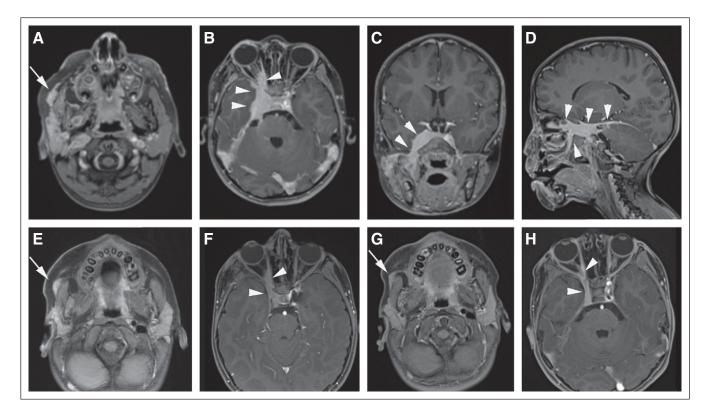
Perineural spread of squamous cell carcinoma (A to D) at time of diagnosis and (E to H) after therapy, shown by contrast-enhanced T1-weighted magnetic resonance imaging. (A) Axial image through face at level of parotid gland shows asymmetric nodular enhancement throughout right parotid gland, as well as more anterior nodular superficial enhancing tissue (arrow). (B) Axial, (C) coronal, and (D) sagittal images through head at level of cavernous sinus and right pterygopalatine fossa show extensive abnormal enhancing tissue within cavernous sinus, extending anteriorly into the right orbital apex, as well as posteriorly toward posterior fossa (arrowheads). (E and F) Five months after initiation of therapy, imaging shows dramatic reduction in tumor burden, both (E, arrow) in superficial tissues of face and (F, arrowheads) within cavernous sinus and orbital apex. (G and H) Thirteen months after initiation of therapy, disease burden had diminished further, both (G, arrow) in superficial tissues of the face and (H, arrowheads) within the cavernous sinus and orbital apex.
